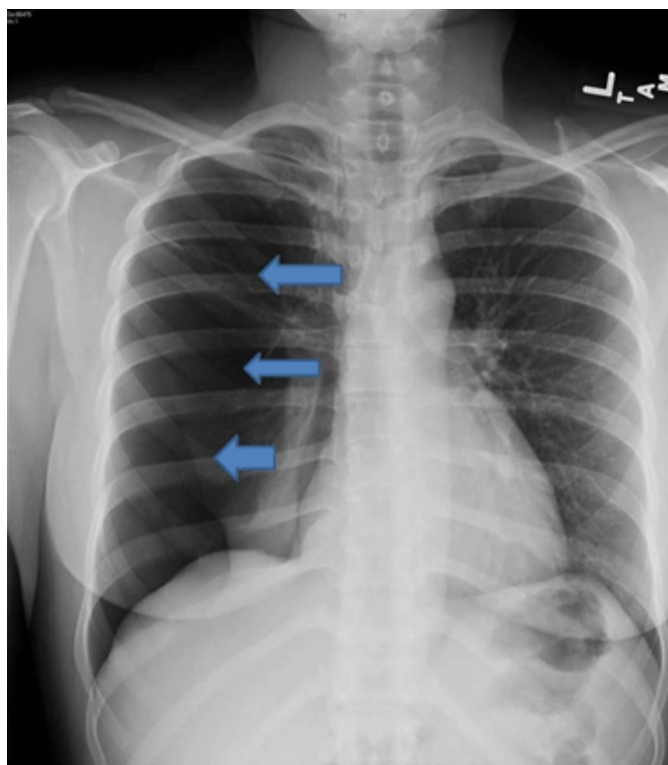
Chest X-ray showing 90% of pneumothorax on the right side.
